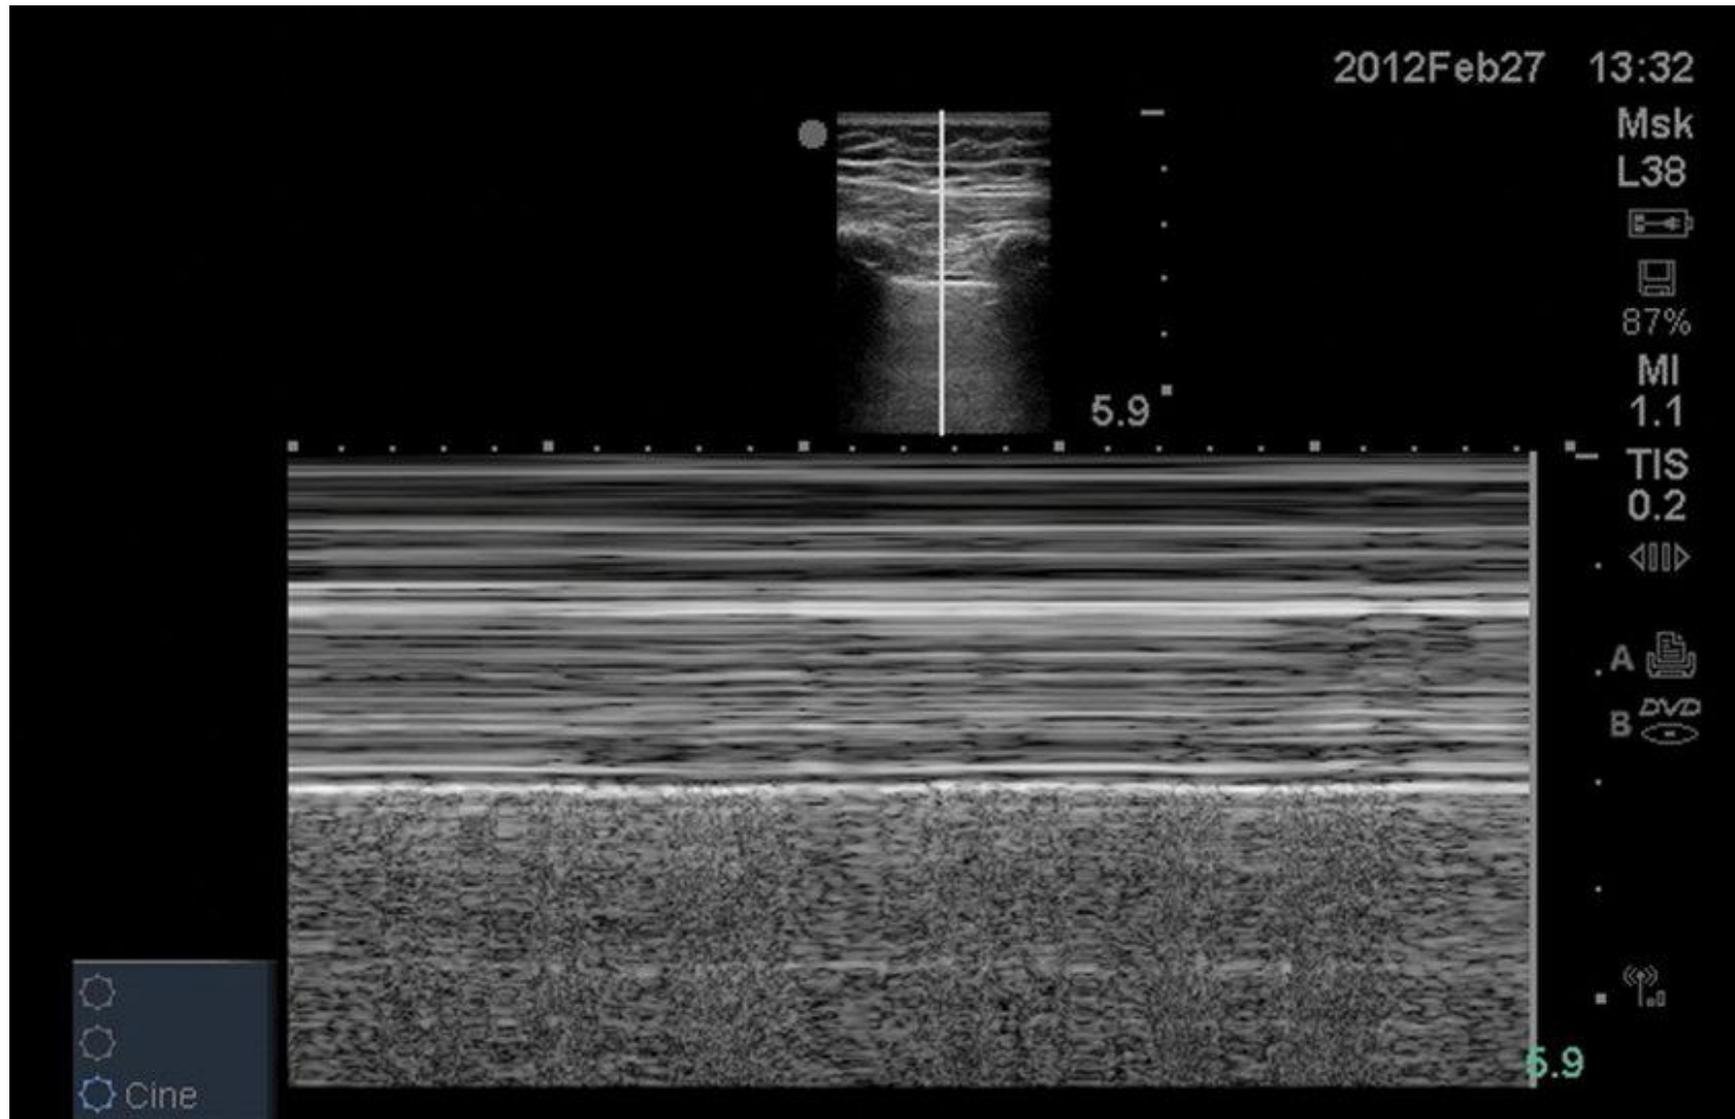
Ultrasound showing the pleura as a bright hyperechoic line
